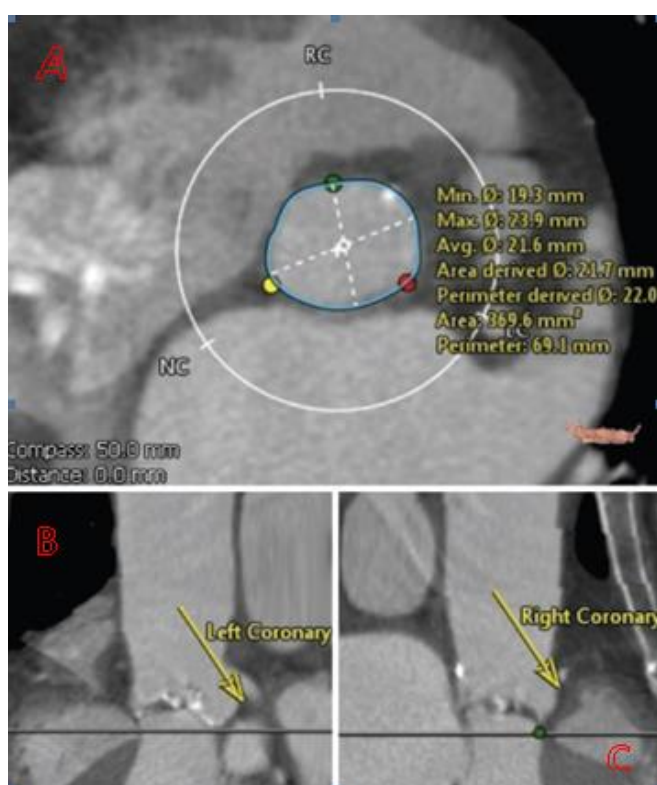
Aortic annulus measurement with multidetector cardiac computed tomography (MDCT). The optimal size for a transcatheter heart valve can be determined using MDCT images to assess the aortic annulus (landing zone) (a). The distance between the aortic annulus and the starting points of the left (B) and right (C) coronary arteries is also measured. To reduce the danger of coronary occlusion during valve deployment, preparations are made using this knowledge.
